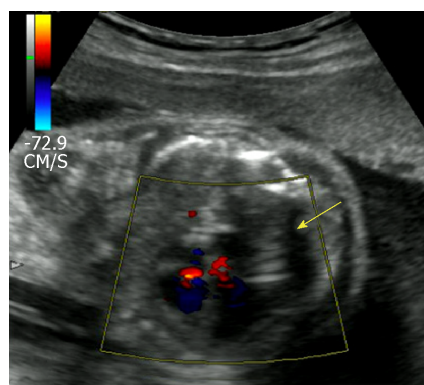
Postoperative ultrasound of the fetus. The normal heart blood flow of the fetal is shown (yellow arrow).
